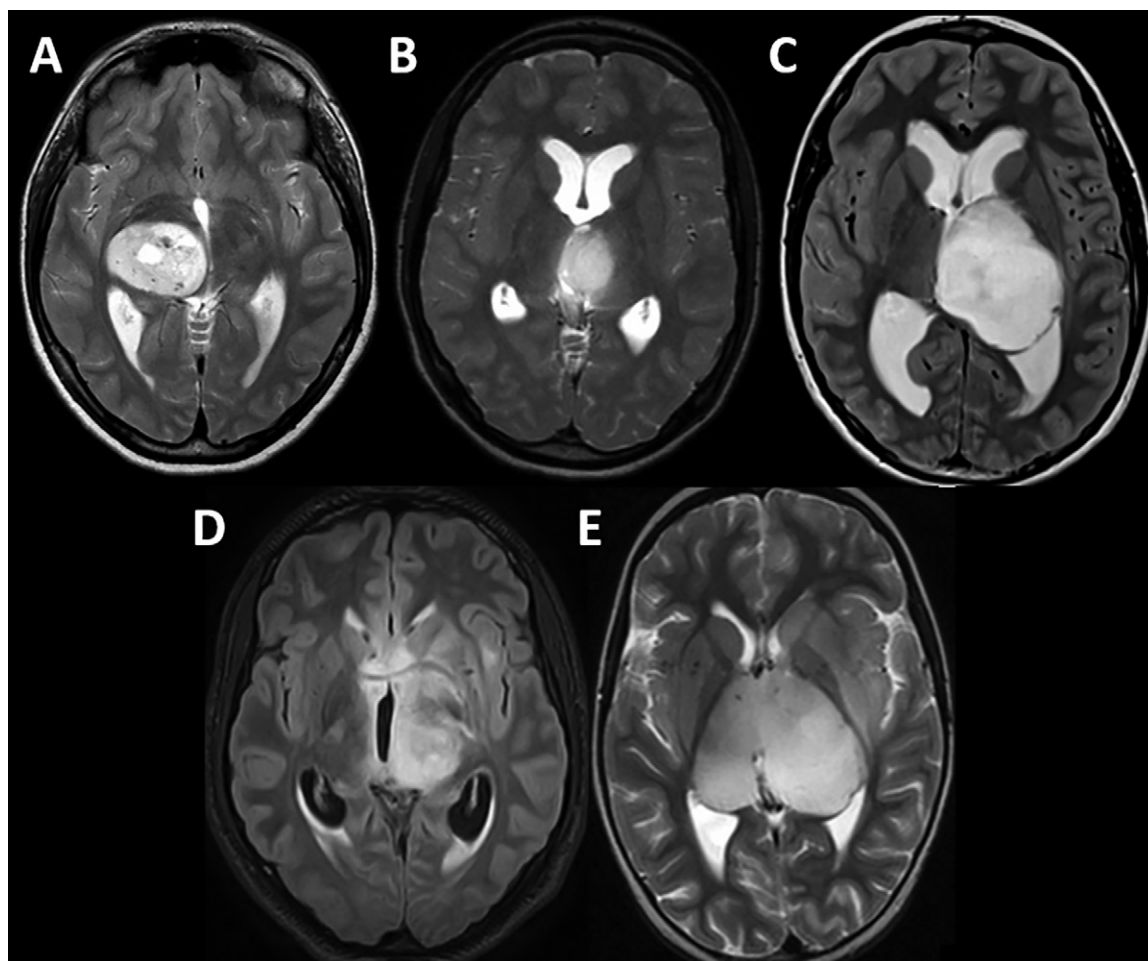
Classification of thalamic-based gliomas with exemplar imaging of the five anatomic locations. Axial T2-weighted images at the level of the tumor isocenter show (A) thalamopulvinar tumor in a 14-year-old girl, (B) anteromedial tumor in a 10-year-old boy, (C) whole-thalamus tumor in a 12-year-old boy, (D) unithalamic tumor with diffuse contiguous spread into the adjacent capsular and anterior striatal region in a 15-year-old girl, and (E) bithalamic tumor in a 17-year-old girl, with involvement of the posterior putamen and insular cortex on the left.
